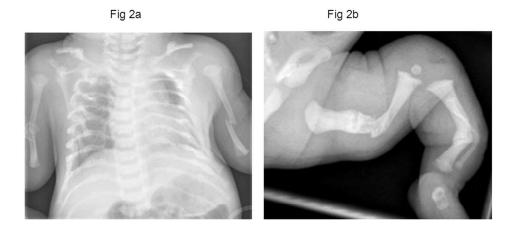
Radiographs at day 1 demonstrating 1a: AP Chest (aged 1 day): Multiple acute and healing ribs, humeral and clavicular fractures. Although the bones are slender, there is normal bone density. Note preservation of vertebral body height.
